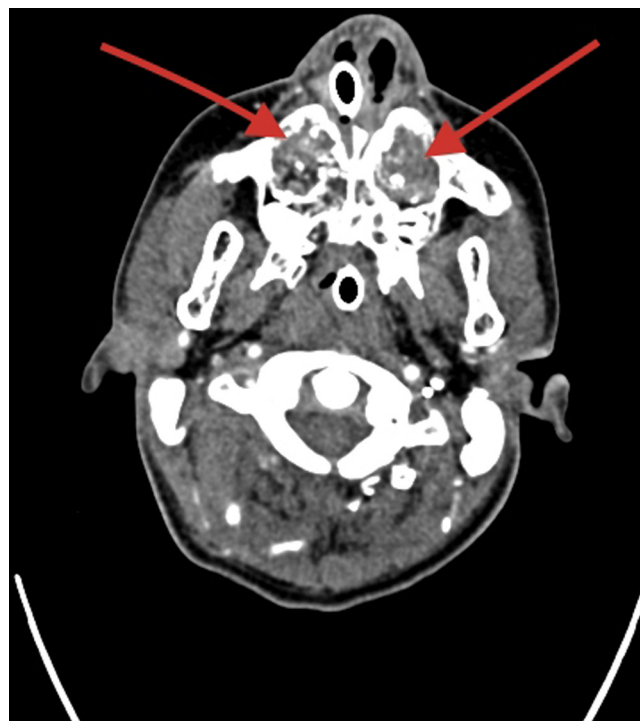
The angio-CT axial view of the maxillary lesion.
